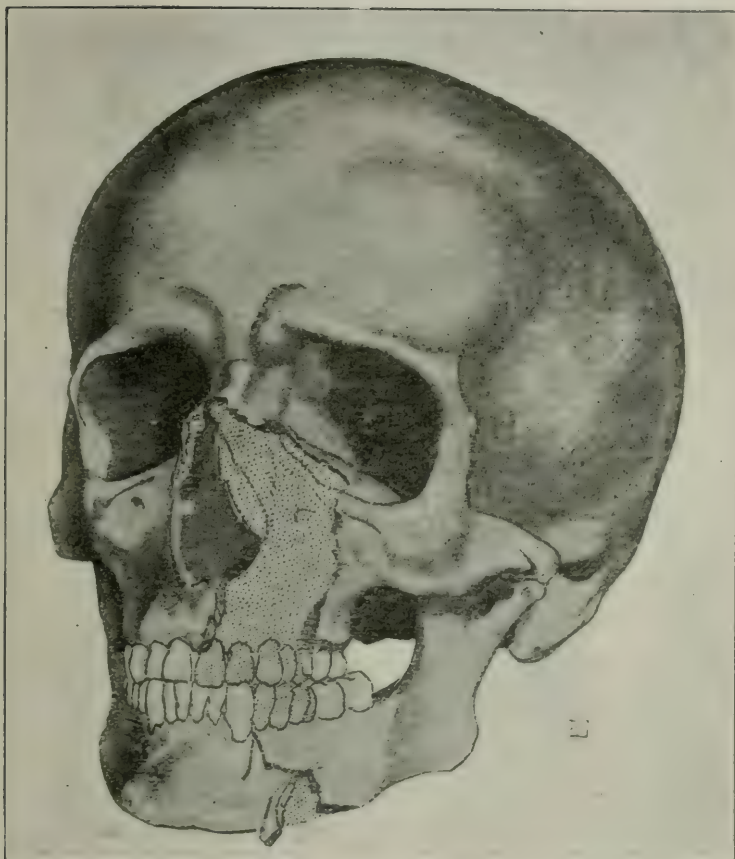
Shows the bone defect and the line of fracture on the horizontal ramus of the lower jaw. This figure, made from an X-ray picture by Prof. Bergonié, indicates the importance of the skeletal lesions clearly. There is almost complete destruction of the bone mass of the upper jaw, indicated on the figure by the dotted area; the nasal bones proper have also been broken and carried away.
